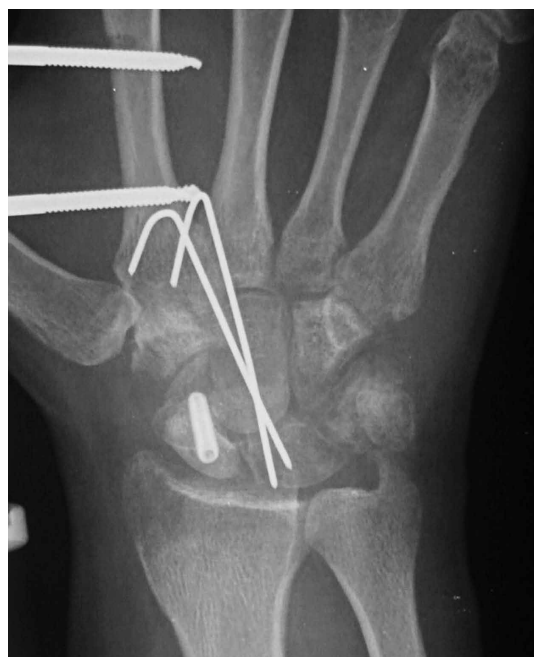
Anteroposterior radiograph of the right wrist at 6-week follow-up.
